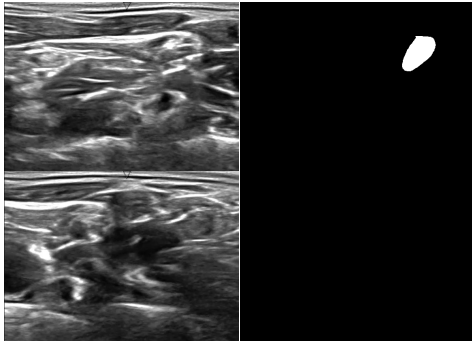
Sample Ultrasound Mask Pairs
